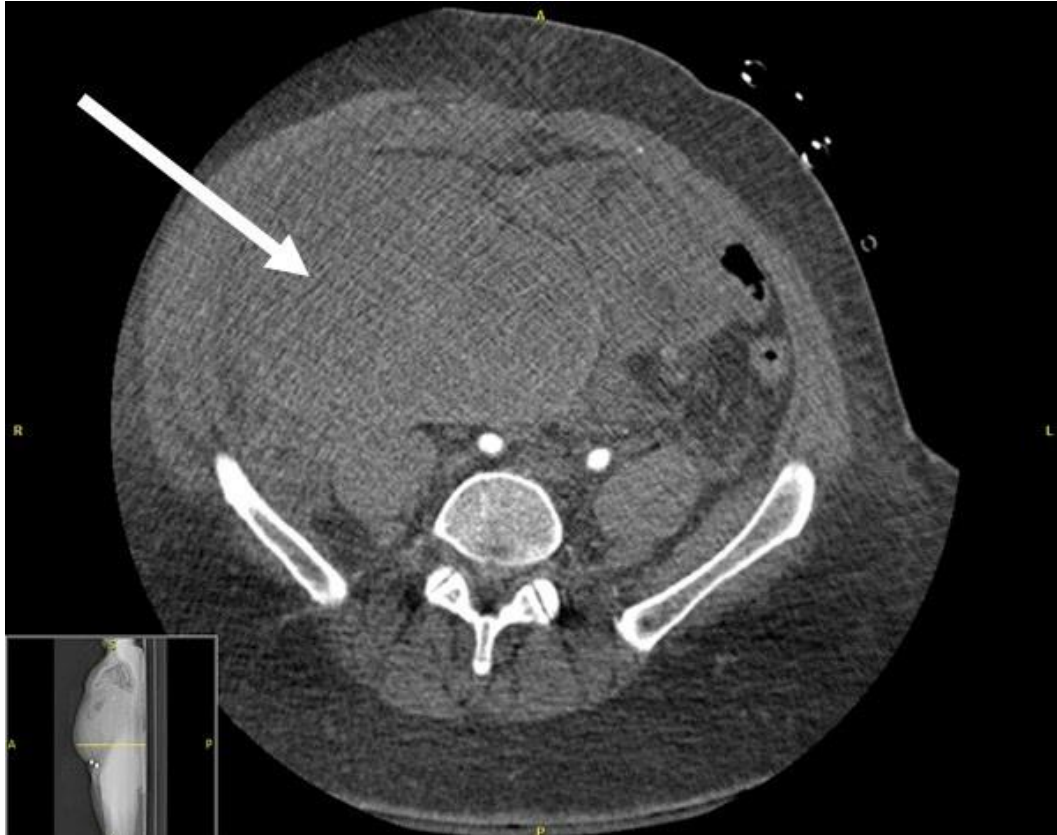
Representative image from the abdominal CT scan showing a large hematoma (white arrow).
